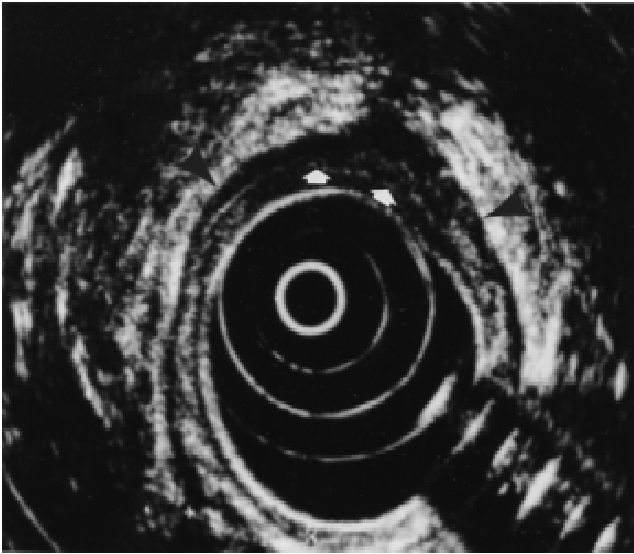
Endoscopic rectal sonogram and endorectal MR image from a patient understaged with endorectal sonography. A. Axial endorectal sonogram of the rectum demonstrates a hypoechoic tumor (arrows), which is apparently contained within the muscularis propria layer (arrowheads) and was interpreted as a stage T2 lesion. B. Axial T2-weighted MR image in the same patient reveals a well-circumscribed carcinoma. The muscularis propria layer is well demarcated (arrows) but is obliterated where it abuts the thickest area of the tumor (arrowhead), indicating a stage T3 carcinoma. Upon resection, this lesion was found to extend through the muscularis layer (stage T3).
